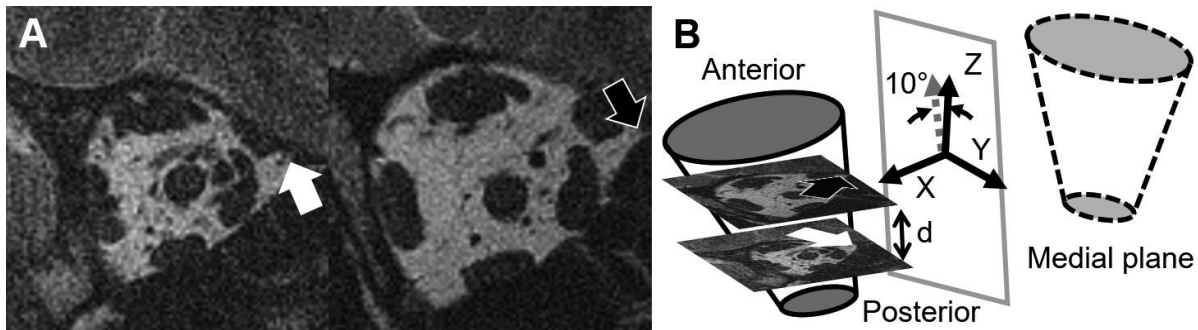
Definition of the coordinate system. (A) Quasicoronal MRI from a right eye. The arrows represent the anterior ethmoid recess in two different image planes. (B) By reflecting the orbital wall point-set, a medial plane is defined, and its normal defines the X-axis. Because coordinates of the anterior ethmoid recess and the distance between image planes are known, the pitch angle of the orbit can be calculated. The gray dashed arrow represents the vector between 3D coordinates of the anterior ethmoid recess in separate quasicoronal image planes, and the vector's direction is used to define Z-axis after rotating 10° in the medial plane. The Y-axis is orthogonal to the X- and Z-axes, and is positive to-wards the top of the head.
